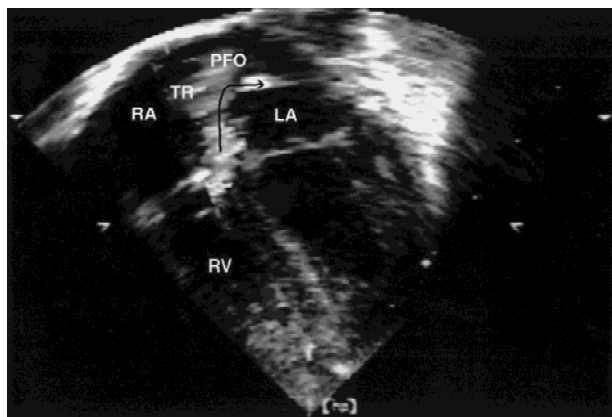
Apical four-chamber view with color-flow Doppler demonstrates severe tricuspid regurgitation (*TR*) and right-to-left shunting across the patent foramen ovale (*PFO*). Arrow denotes direction of shunt. *LA*, left atrium; *RA*, right atrium; *RV*, right ventricle.
